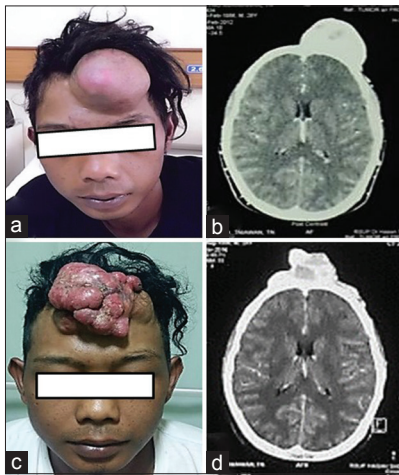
(a) Lump in mid frontal region in male patient (before excision in 2012), mass size $12 \times 10 \times 6$ cm. (b) Head CT scan showing soft tissue attenuation irregular mass single lesion lobulated in mid frontal region. (c) Lump in mid frontal region in same patient after operated 4 years ago with mass size $12 \times 10 \times 5$ cm. (d) Head CT scan showing soft tissue attenuation irregular mass multiple lesion lobulated in mid frontal
